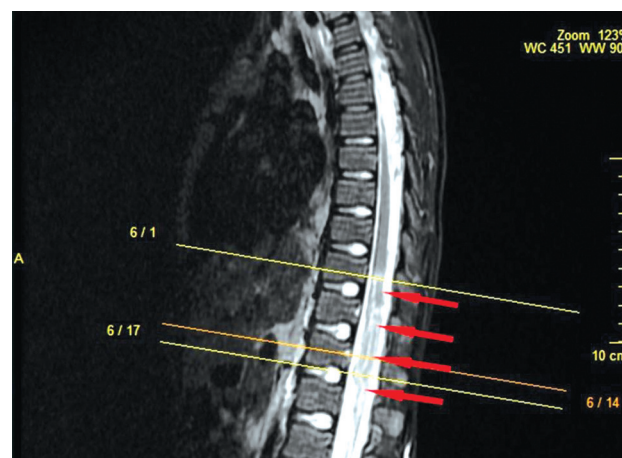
MRI scan of the spinal cord, acute period. Sagittal T2W_TSI images showing myelopathy at the Th10–L1 level
